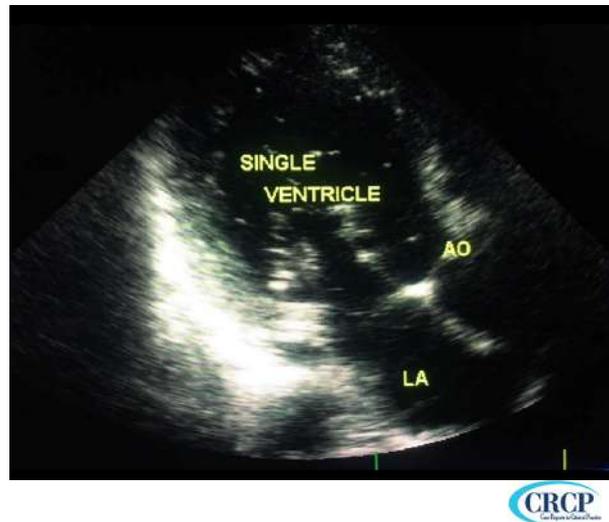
The echocardiography of patients
